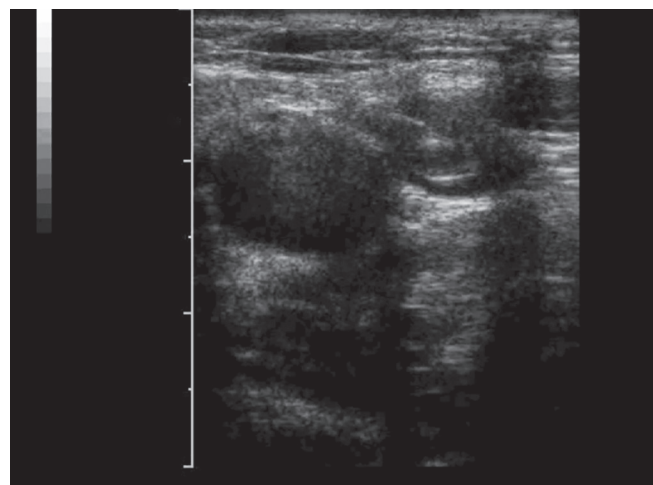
Ultrasound image depicting image-guided needle insertion into small lymph node lateral to the internal jugular vein. Once the needle tip is seen within the center of the lymph node, ETOH or blue dye is injected
